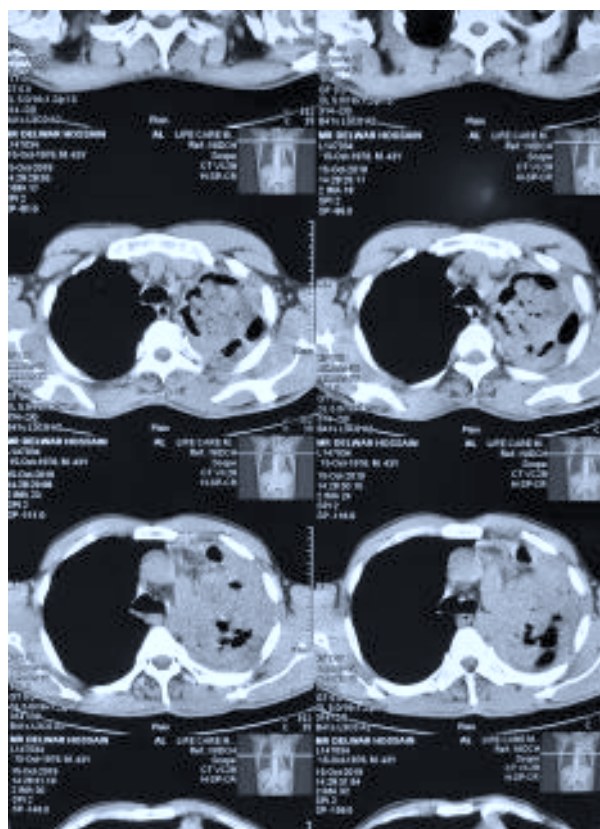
CT scan chest of patients
